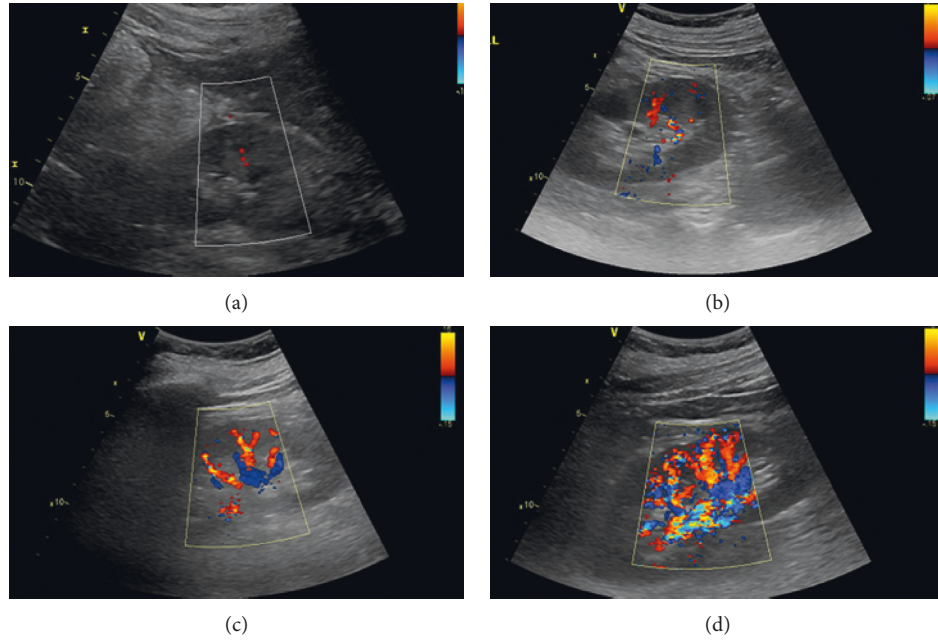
Semiquantitative color Doppler (SQC) grade. (a) Unidentifiable vessels were seen in the kidney; SQC grade was 0. (b) Vessels were seen in the renal hilum, but no vessels were seen in the parenchyma; SQC grade was 1. (c) Interlobar vessels were seen in most of the renal parenchyma; SQC grade was 2. (d) Arcuate arteries were seen in the entire field of view; SQC grade was 3.
